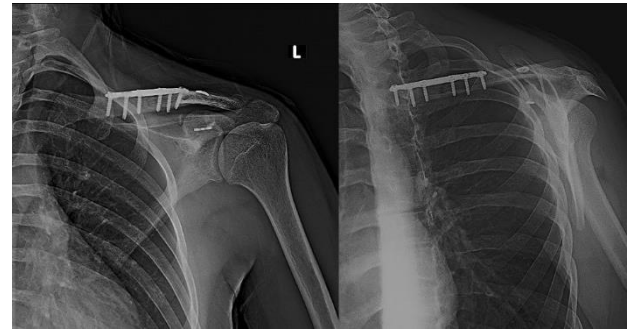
Postoperative shoulder anteroposterior and lateral radiographic images.
